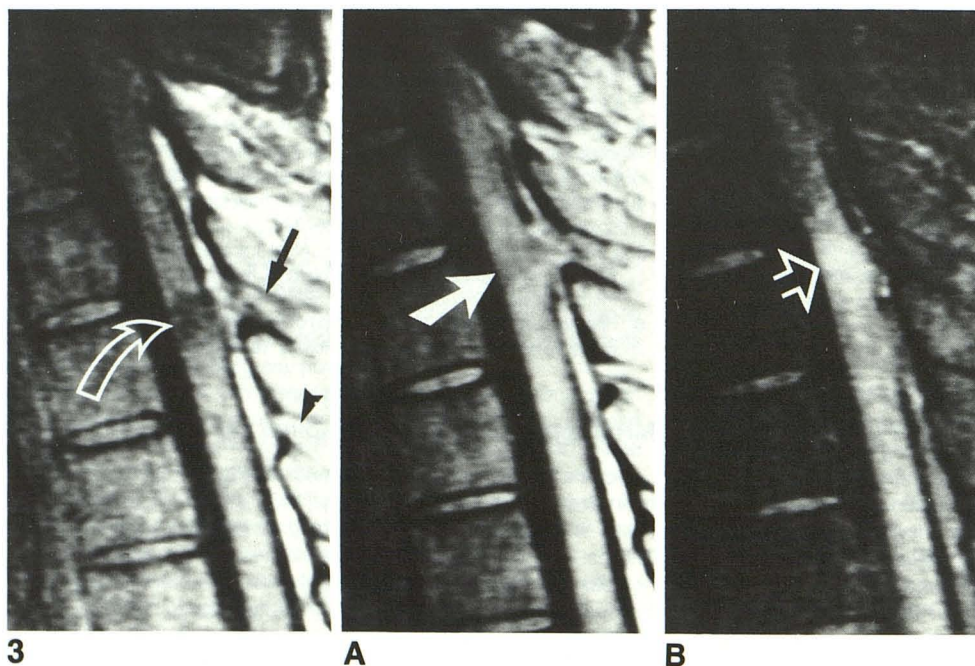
Sagittal T1-weighted image (SE 20/800) obtained 3 months after stab wound shows decreased signal intensity within spinal cord at level of original injury (curved arrow). Abnormal signal intensity seen in region of interspinous ligament (black arrow) probably represents scar tissue replacing the normally observed bright fat signal (arrowhead).
